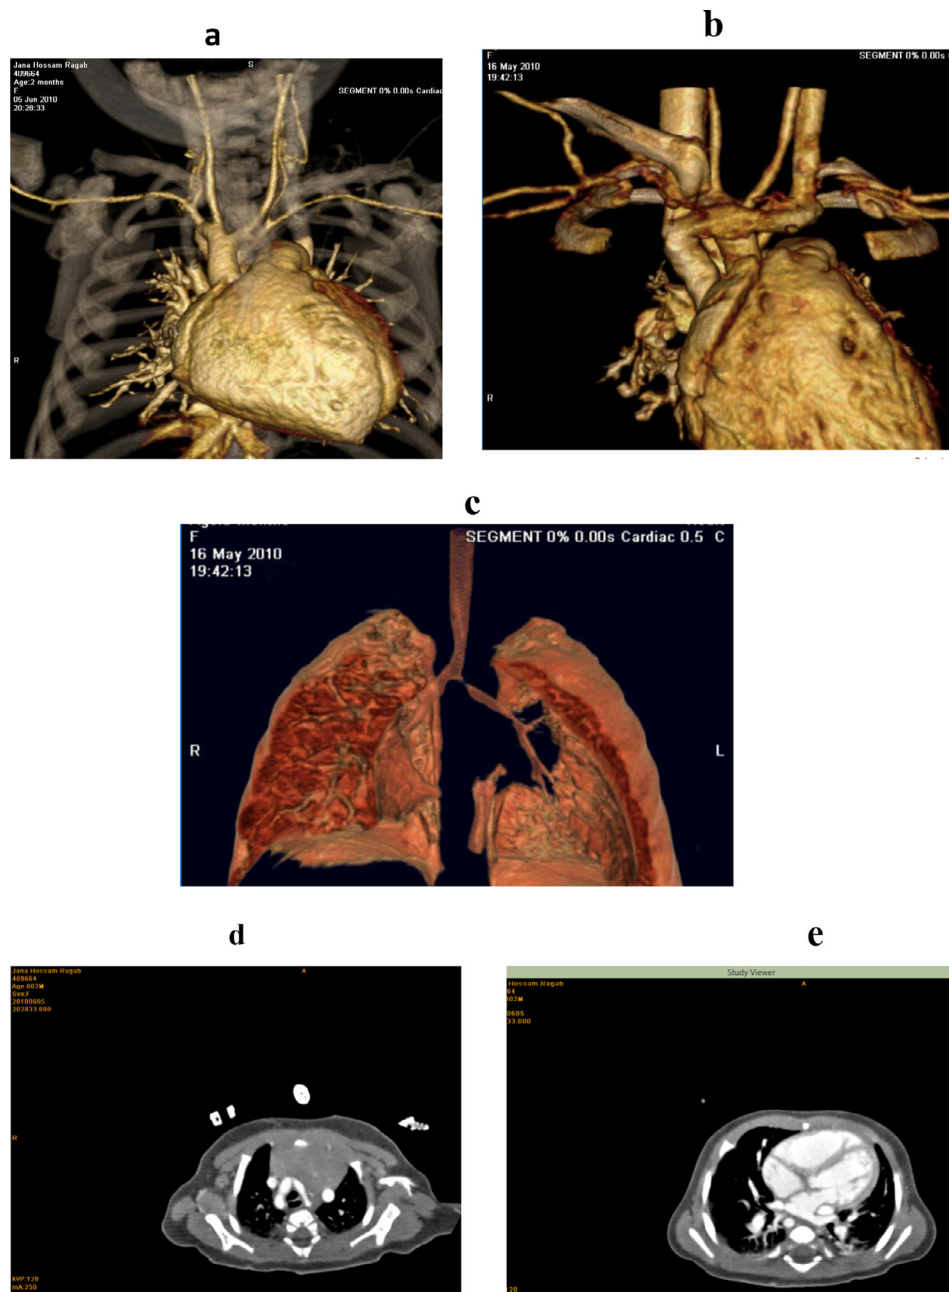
DAA with Anomalous pulmonary venous drainage. (a and b) Volume rendered MDCT image shows aortic arch bifurcates to Right & left branches with abnormal drainage of pulmonary veins into the left atrium. (c) Volume rendered 3 dimensional MD CT revealed lower tracheal stenosis by the surrounding double Aortic arch; pulmonary parenchymal congestion. (d and e) Axial cuts image show DAA encircle both trachea and esophagus with abnormal pulmonary venous drainage into left atrium and bilateral hilar venous congestion.
